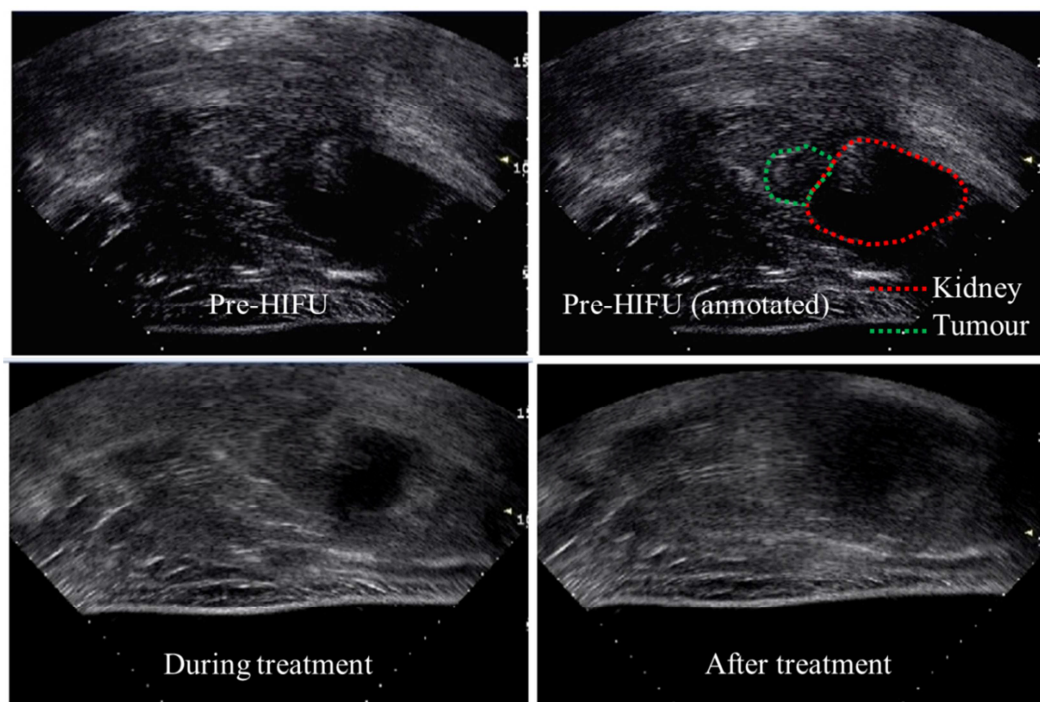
Ultrasound images from Patient 5.21 demonstrating change in image quality during treatment (Model JC-200 HIFU device). Pre-HIFU image quality is good but deteriorates during treatment (3/5 during; 2/5 after). After treatment, the kidney and tumour are completely obliterated due to tissue oedema.
